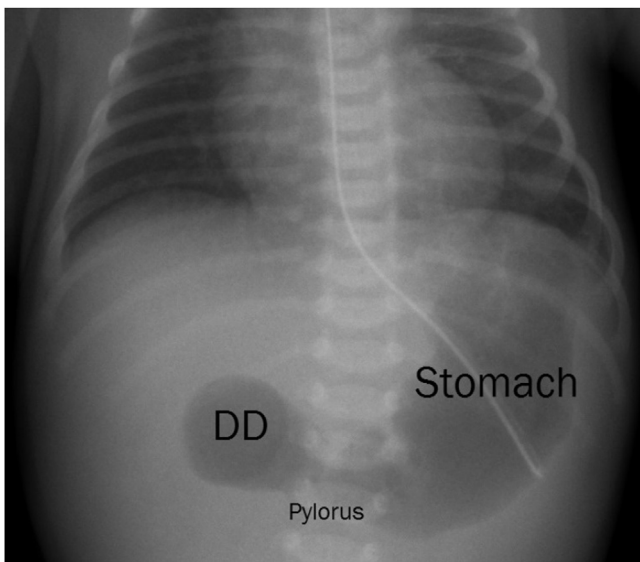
Postnatal radiography showing a double-bubble in the upper abdomen. DD. Duodenum.
